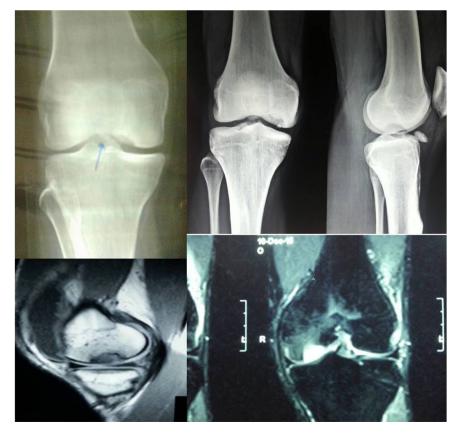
Preoperative radiographs and MRI scan of knee showing displaced osteochondral fragment (OCF) and defect in the medial femoral condyle (MFC).
